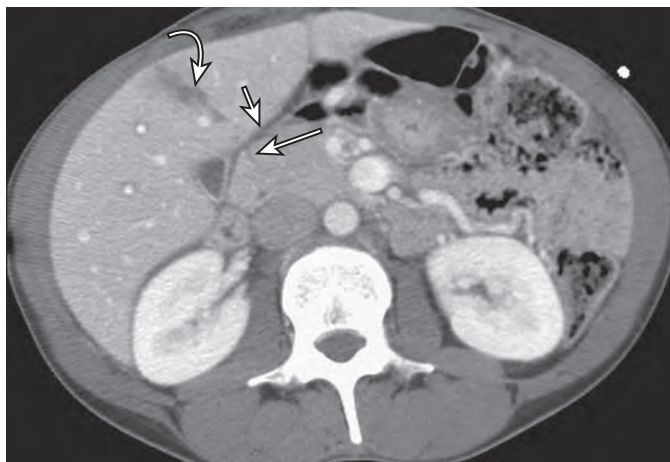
CT of superficial pancreatic laceration. CT scan of a 27-year-old patient with a stab wound to the abdomen shows a laceration through the hepatic parenchyma (curved arrow), with concomitant superficial laceration of the pancreatic head (long arrow). A small amount of fluid is seen between the pancreas and liver (short arrow). Subsequent endoscopic retrograde pancreatogram was negative.
